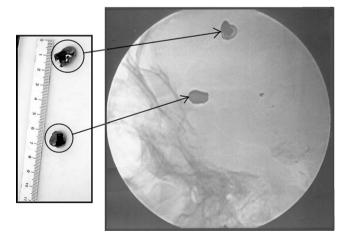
X-ray showing two foreign bodies corresponding to the core and the jacket of the projectile.
